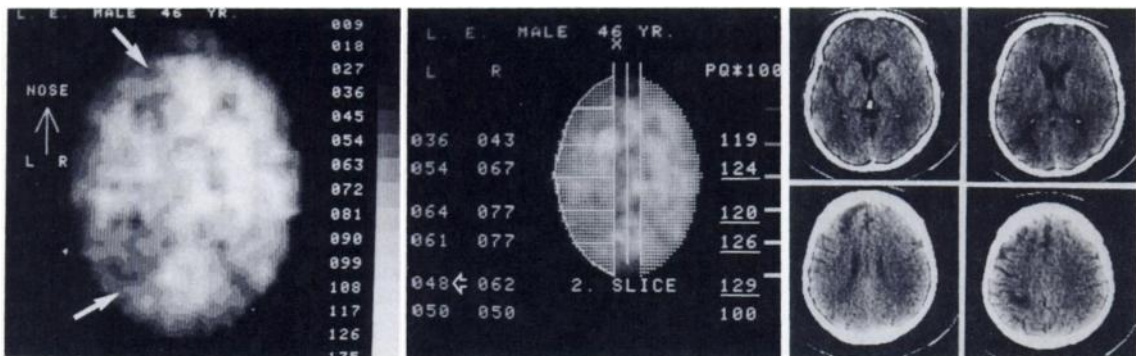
Six months before examination 46-yr-old male patient developed right-sided PRIND (weakness of right extremities). Radiographic angiography showed occluded left internal carotid artery. SPECT flow map (left, Slice 2) revealed visually low-flow areas within left hemisphere (arrows). With ROI technique (12 areas per slice) only one area (arrow: 48 ml/100 g/min) was below normal (center). However, four (underlined) right-to-left area ratios (PQ = AR) were significantly outside of normal ranges (mean + 2s.d., see Table 2, Slice 2). TCT (right, plain imaging) revealed signs of low perfusion in left hemisphere (widened sylvian fissure, enlarged anterior ventricle) but only two defect areas (frontal and occipito-parietal).
